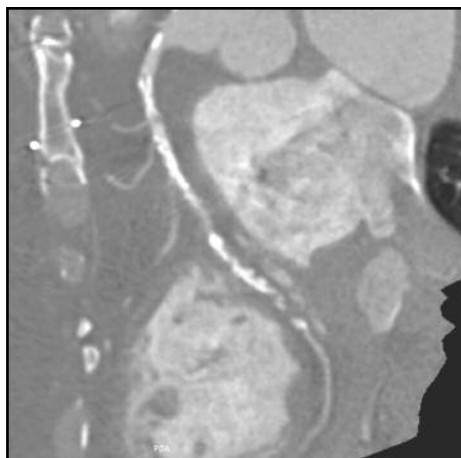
Diffuse, heavy calcification (bright white areas along the vessel) of the right coronary artery precludes lumen analysis with computed tomographic angiography.
